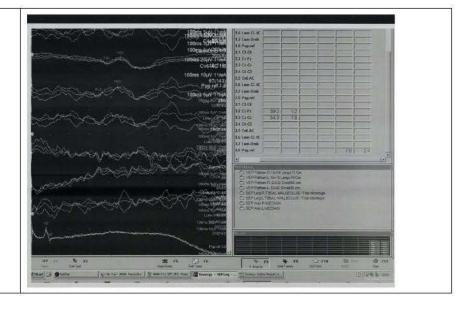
Dr. Catania could easily be negated with Surrounding Medical Data and Clinical Presentation What if we consider surrounding clinical data? Does it strengthen or weaken my case? If you have a malformed graph there must be a lesion present in the immediately preceding MRI.
